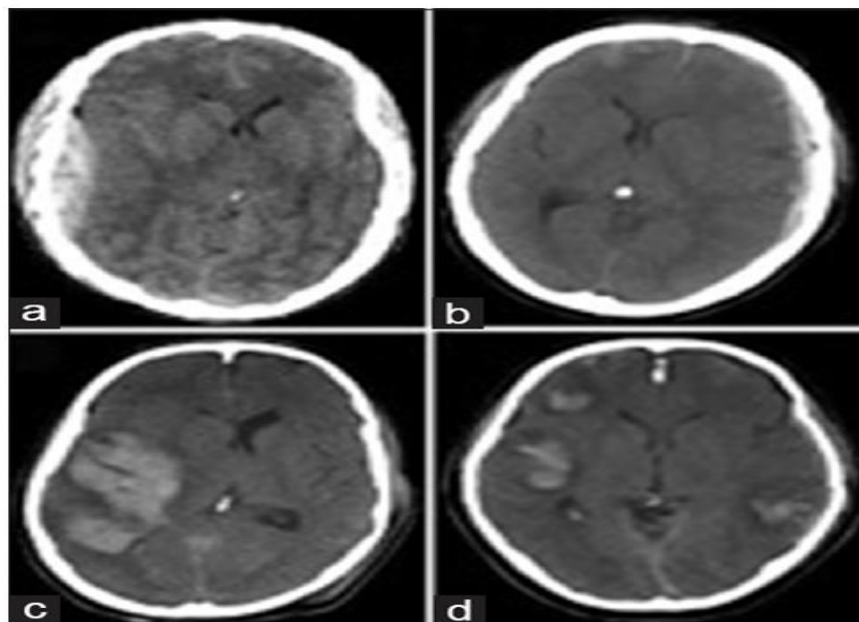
Axial cranial computed tomographic images of the different intracranial hemorrhages in the study.
